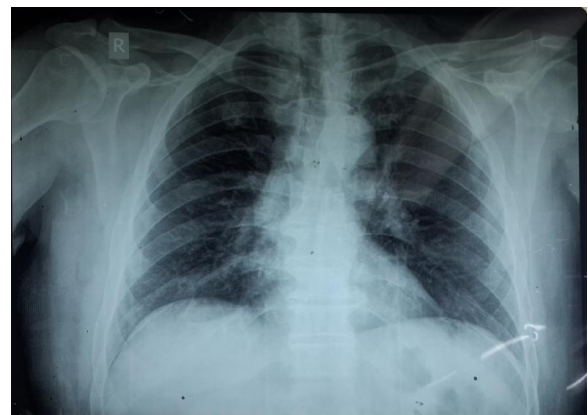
X-ray on follow-up
